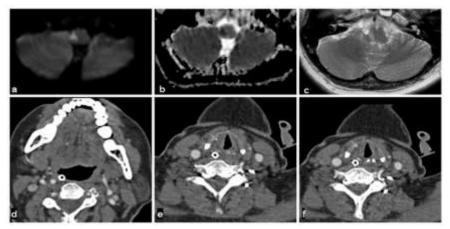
Diffusion weighted images (a), apparent diffusion coefficient maps (b) and T2-weighted images (c) show acute infarction of posterolateral medulla infarction on the right side. CTA source images show double lumen appearance with superimposed thrombus in the right vertebral artery (black arrow, d,e) along with medialization of right true vocal cord (white arrow, e,f).
